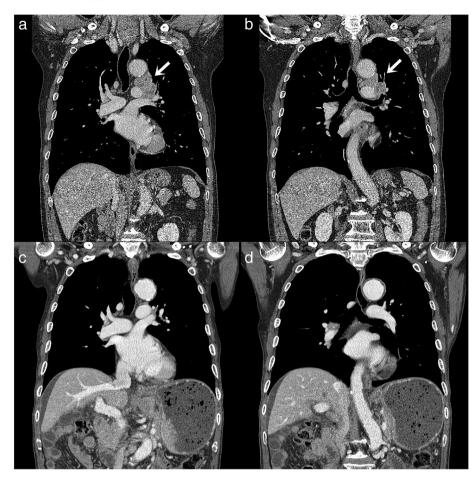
(a and b) Chest computed tomography (CT) scan shows a tumor in the left upper lobe with enlarged lymph nodes in the left hilum and mediastinum. (c and d) Chest CT scan shows the previous tumor lesion has completely disappeared
